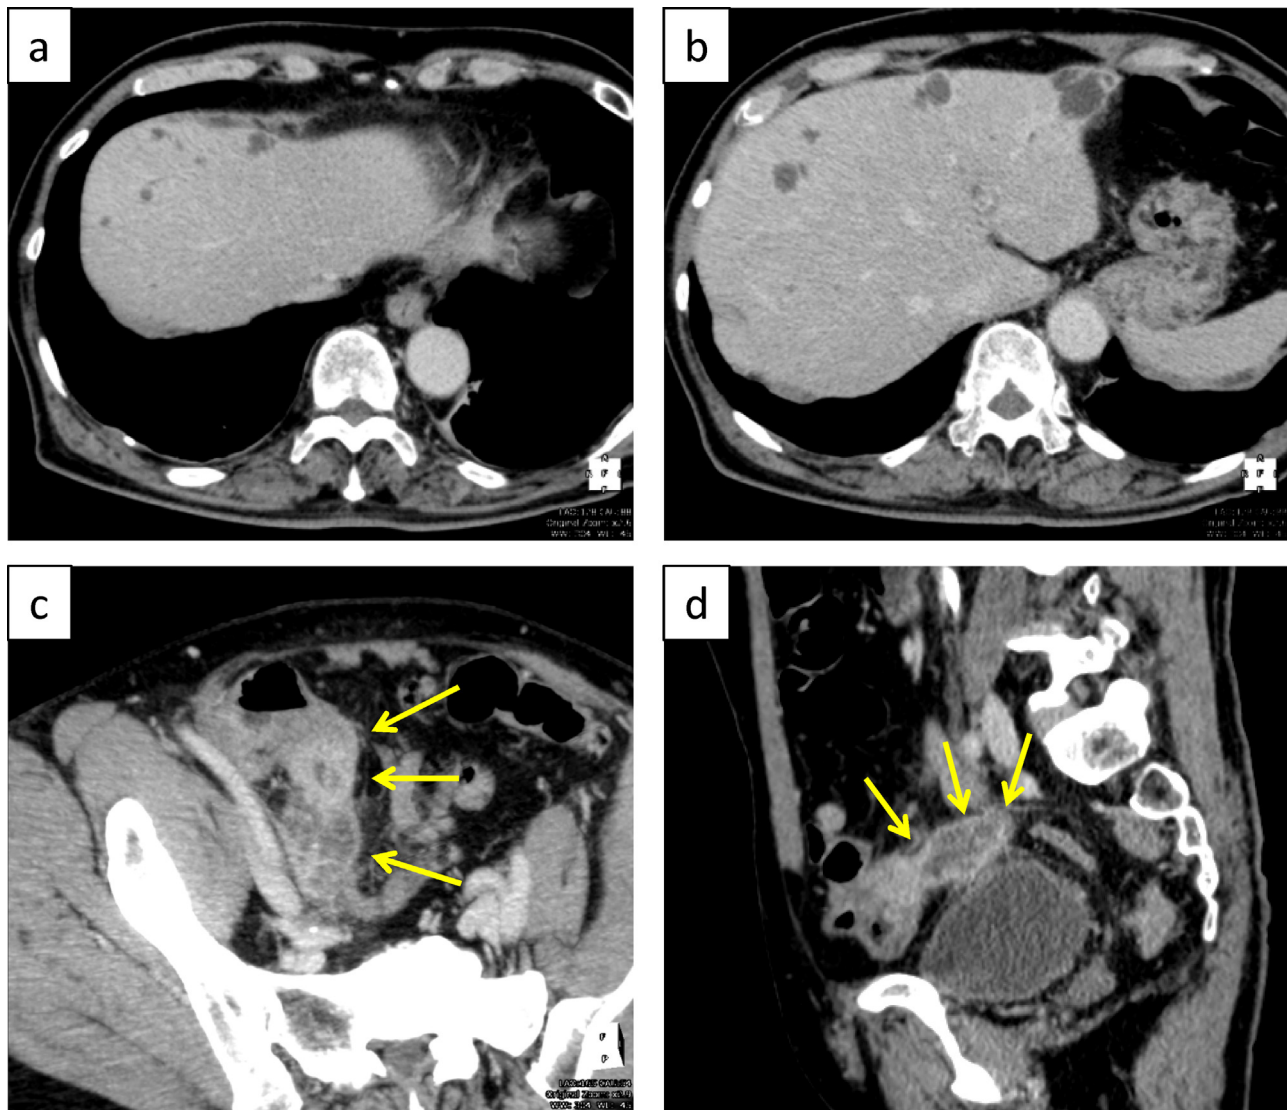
Computed tomography (CT) image. CT scan showing (a, b) multiple liver abscesses and (b, c) an enlarged appendix with a pseudotumoral appearance (septum-like structure) (yellow arrow).
